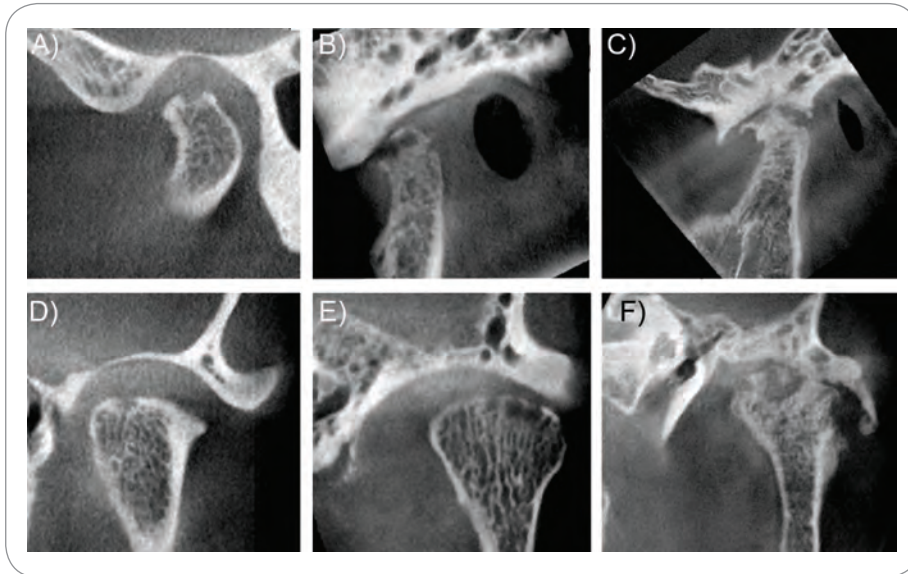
Progressive osteoarthritic changes depicted on lateral (A, B, C) and coronal (D, E, F) CBCT sections. Mild erosion of the condylar head and normal glenoid fossa (A, D), moderate erosion, bone sclerosis, and reduced joint space with lateral position of the condylar head within the glenoid fossa on the coronal section (B, E), and severe erosion, bone sclerosis, osteophyte formation, periosteal bone reaction, and significantly reduced joint space (C, F).
